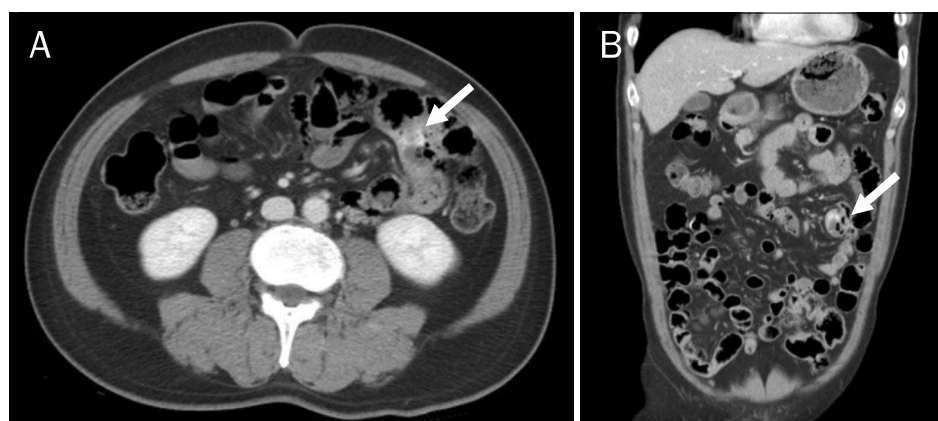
Computed tomography scan with angiography performed at the referral hospital. (A) Axial scan revealed a small high-density area in the jejunal lumen (arrow). (B) A coronal view reconstruction revealed a small high-density area in the jejunal lumen (arrow).
